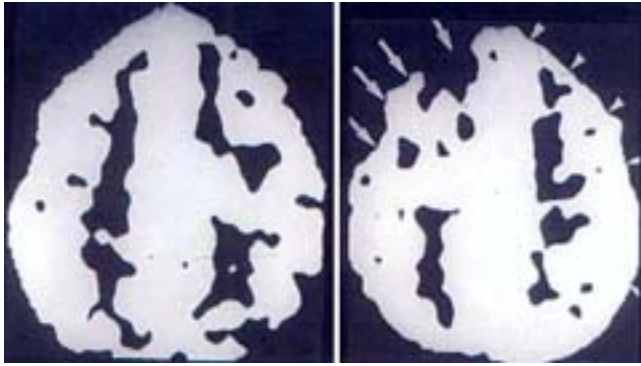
Images of flow maps from cold Xe CT scanning with areas in white set to reflect flows of at least 30 ml/100 gm/min. The first image was obtained as a baseline. The second was generated following an intravenous Diamox challenge. Note the relative decrease in flow to the right frontal region (arrows), signifying a lack of residual autoregulatory reserve ipsilateral to the known AVM. On the contralateral side there is no decrease, but there is also a lack of increase in the frontal region with challenge compared with the parietal area (arrowheads).
